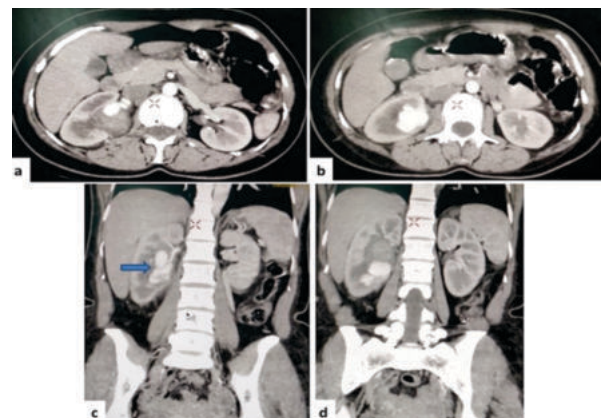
CT angiography images showing large bilobed pseudoaneurysm arising from segmental branch of right renal artery with surrounding hematoma.
